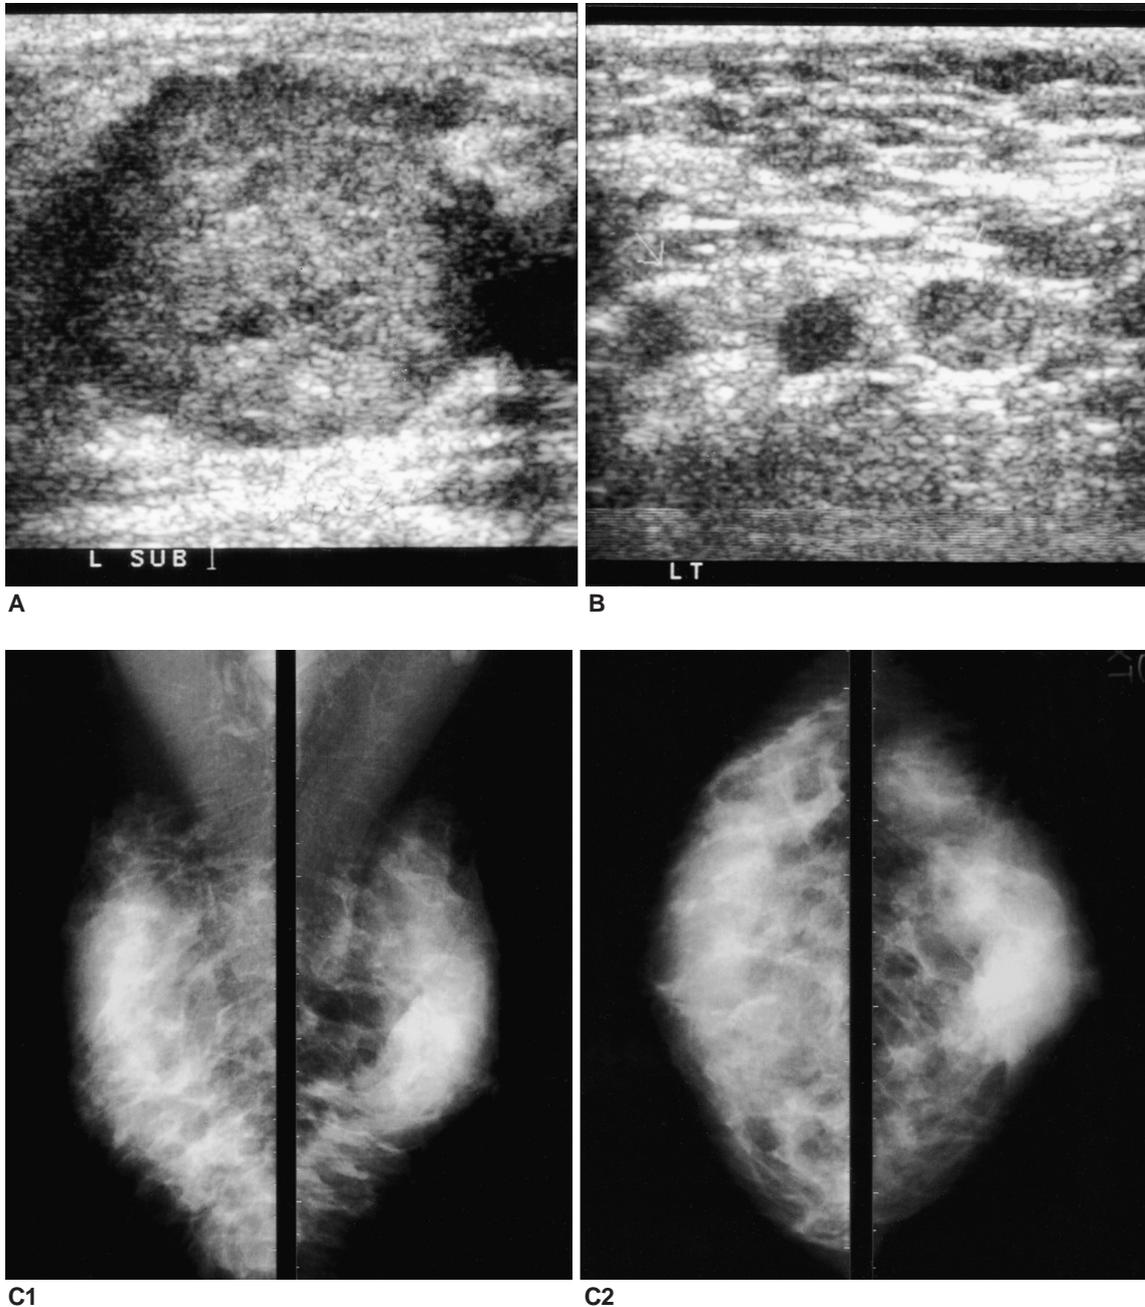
A 35-year-old woman with IUP 36 weeks presented with a palpable lump at the subareolar area in the left breast. A. Sonography of the patient showed an irregular shaped low echoic mass in the left subareolar area. B. Sonography at the left axilla area showed multiple enlarged metastatic lymph nodes. C. Bilateral mammograms showed heterogeneous breast parenchyma with increased density in the left subareolar area with an irregular shaped mass with spiculation (BI-RADS category 4). D. Breast MRI study was performed.
